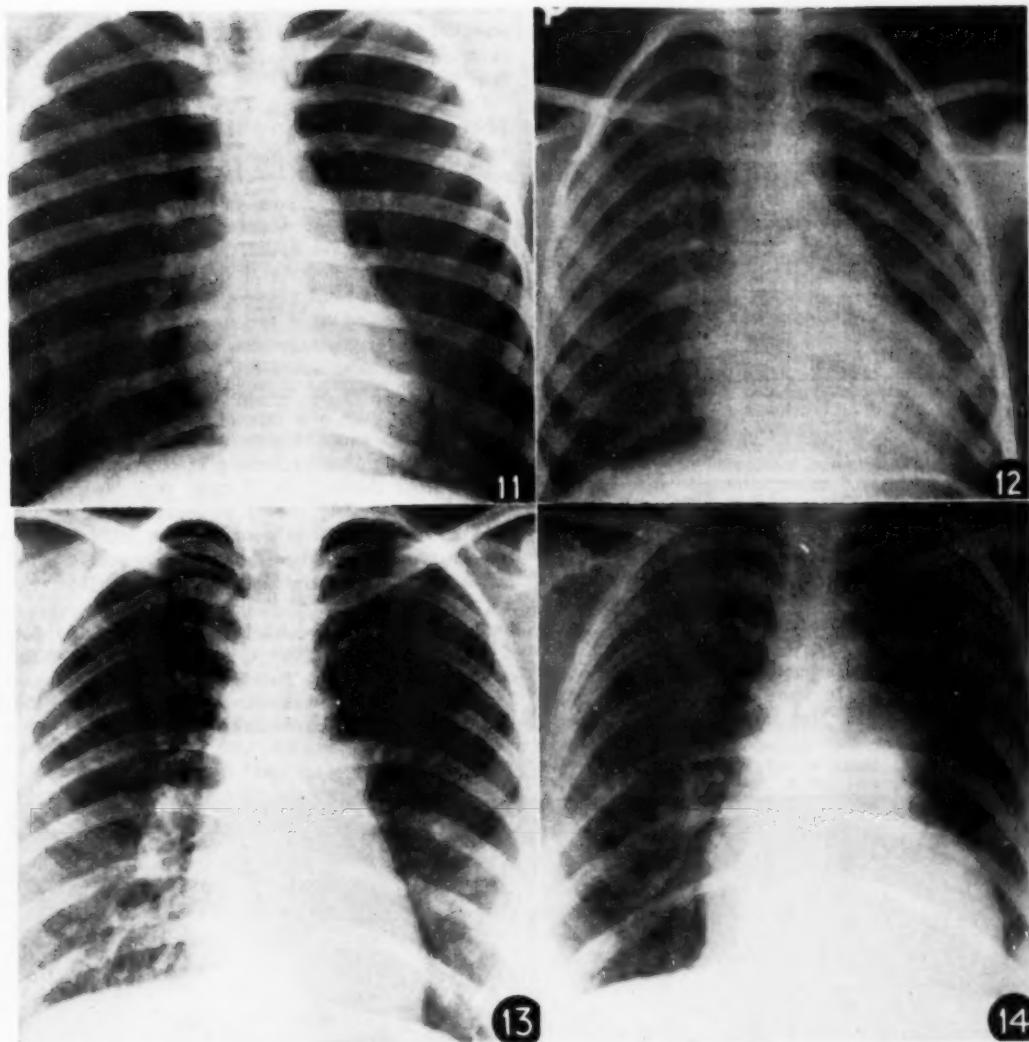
(Case 8): The X-ray shows a prominent pulmonary artery with normal pulmonary vascular markings.
